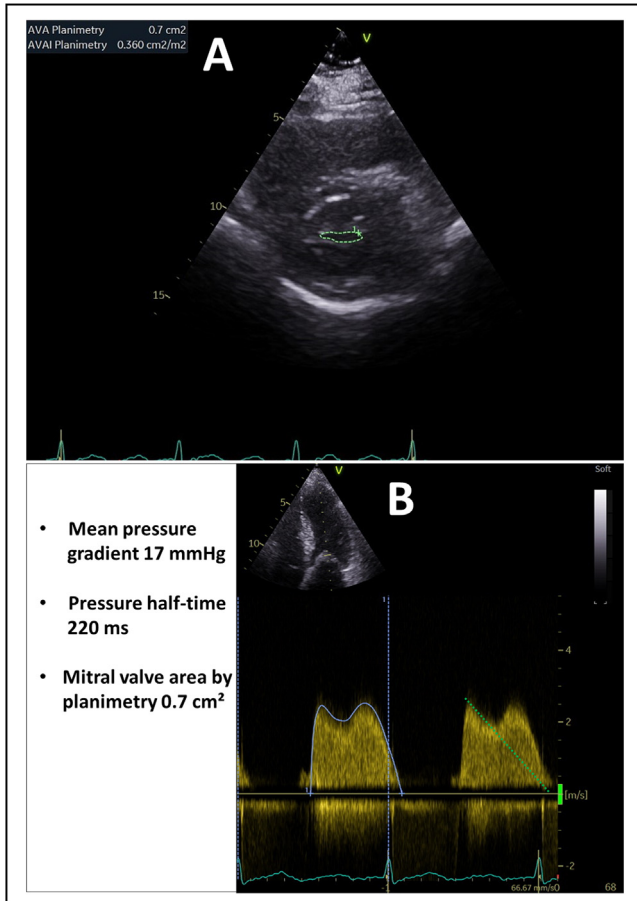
Echocardiographic images of a young female patient with mitral stenosis who presented with dyspnea and a low-pitch (grade 1-2) mid-diastolic rumble. A is a parasternal short-axis view demonstrating stenotic mitral valve with a valve area of 0.7 cm² by planimetry. B is a continuous wave Doppler signal through mitral valve showing pressure half-time of 220 ms and a mean pressure gradient of 17 mmHg, consistent with severe mitral stenosis.
